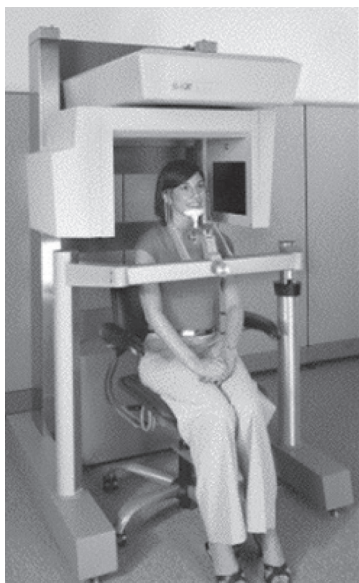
A typical CBCT apparatus.
